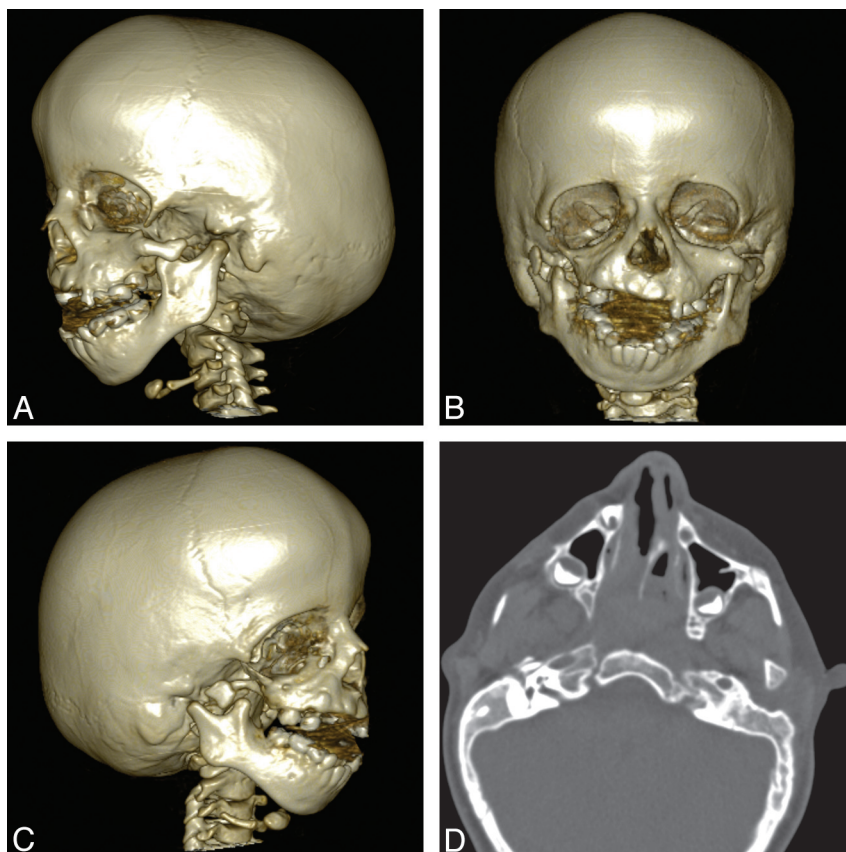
A 4-year-old girl with TCS. A–C, 3D bone reconstructions show bilateral and asymmetric abnormalities of the mandibular condyle and coronoid process as well as maxillary hypoplasia and micrognathia. The EACs are absent bilaterally. D, Axial CT image shows bilateral hypoplastic zygomatic arches, maxillary bone dysplasia, and temporal bone abnormalities.
